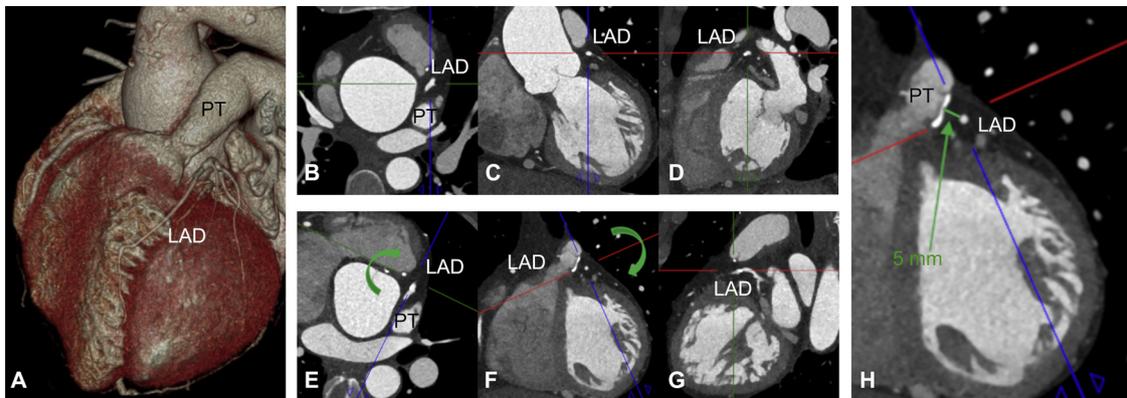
CT Analysis: Relationship between LAD and pulmonary trunk (PT). Volume rendering showing a patient who underwent Ross procedure (A). Initial standard axial (B), sagittal (C) and coronal (D) planes; the imaging crosshairs that are locked at 90° angles are rotated clockwise (see arrow) so the blue line is in-line with the LAD (E, F). By scrolling through these images as well as the third imaging which is perpendicular to the long axis of the coronary artery (G) the site with the shortest distance to the stenotic part of the PT is determined and measured, which in this case was 5 mm (F). PT, pulmonary trunk; LAD, left descending artery.
